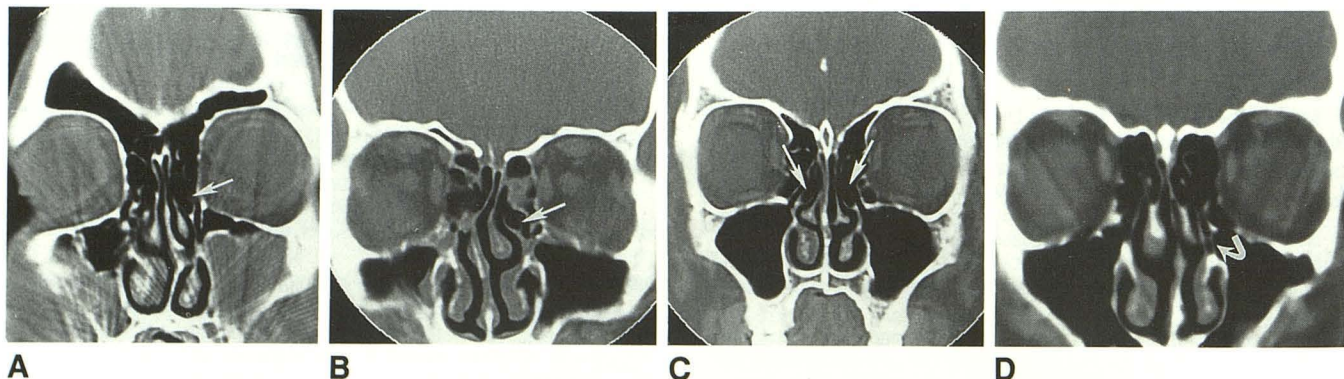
CT scans show four examples of pneumatization of uncinate process. A and B, Unilateral process bullae (arrows) caused by extensive pneumatization. C, Bilateral uncinate process bulla (arrows). D, Unilateral process bulla (arrow) caused by mild pneumatization.
